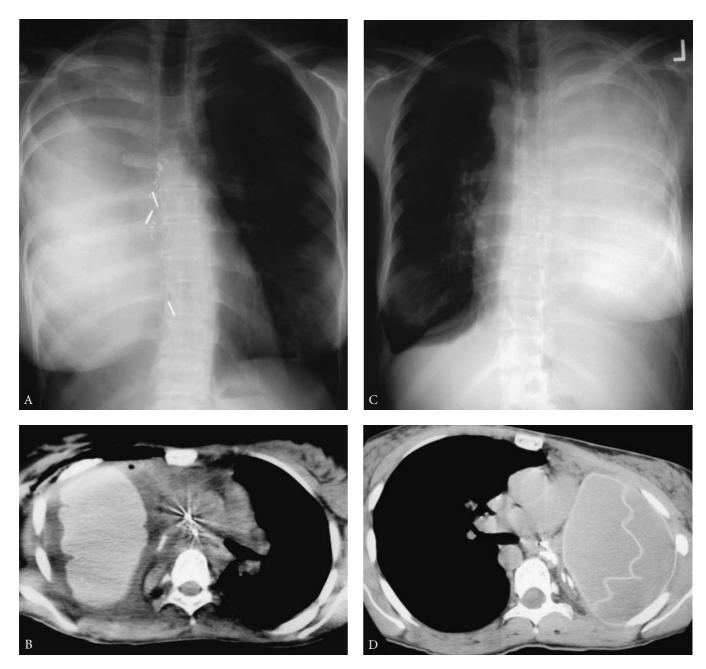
Postoperative images after mediastinal repositioning with implantation of saline-filled breast prostheses. A, Chest x-ray film of the patient seen in Figure 15-15A. The trachea and mediastinum are returned to the midline and the lung to normal volume. B, Computed tomography scan of this patient shows the outline of the prostheses, and return of the left main and upper lobe bronchi to normal location and patency. C, Chest x-ray film of the patient from Figure 15-16A. D, Computed tomography scan shows right main and upper lobe bronchi widely open and to the right of the spine.
